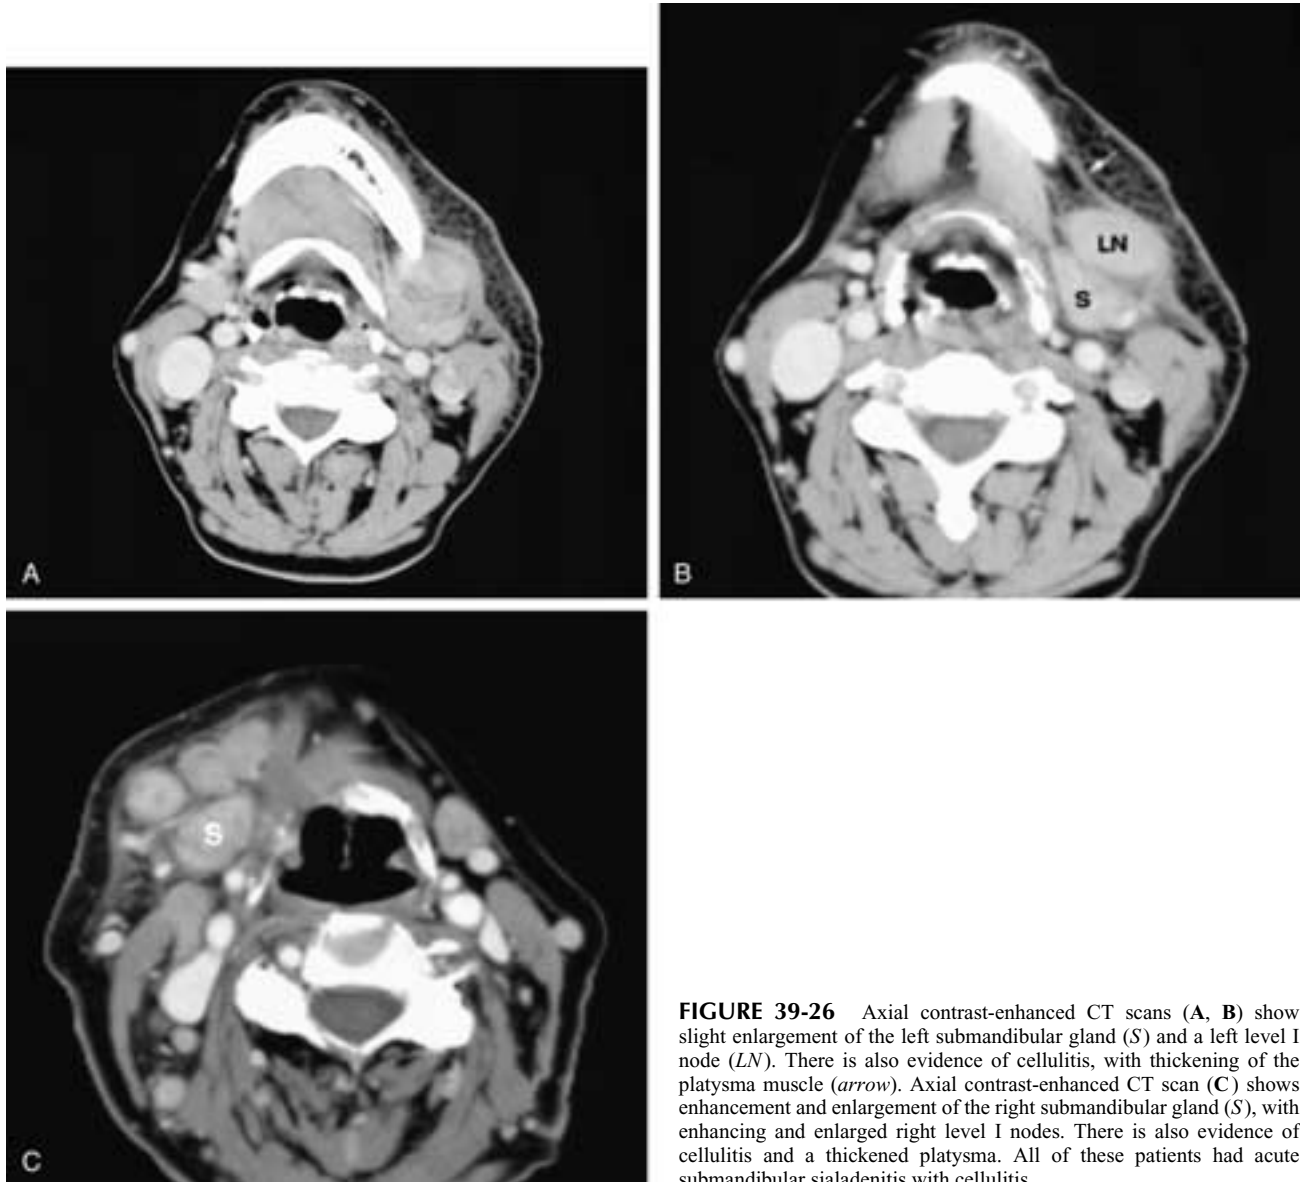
Axial contrast-enhanced CT scans (A, B) show slight enlargement of the left submandibular gland (S) and a left level I node (LN). There is also evidence of cellulitis, with thickening of the platysma muscle (arrow). Axial contrast-enhanced CT scan (C) shows enhancement and enlargement of the right submandibular gland (S), with enhancing and enlarged right level I nodes. There is also evidence of cellulitis and a thickened platysma. All of these patients had acute submandibular sialadenitis with cellulitis.
